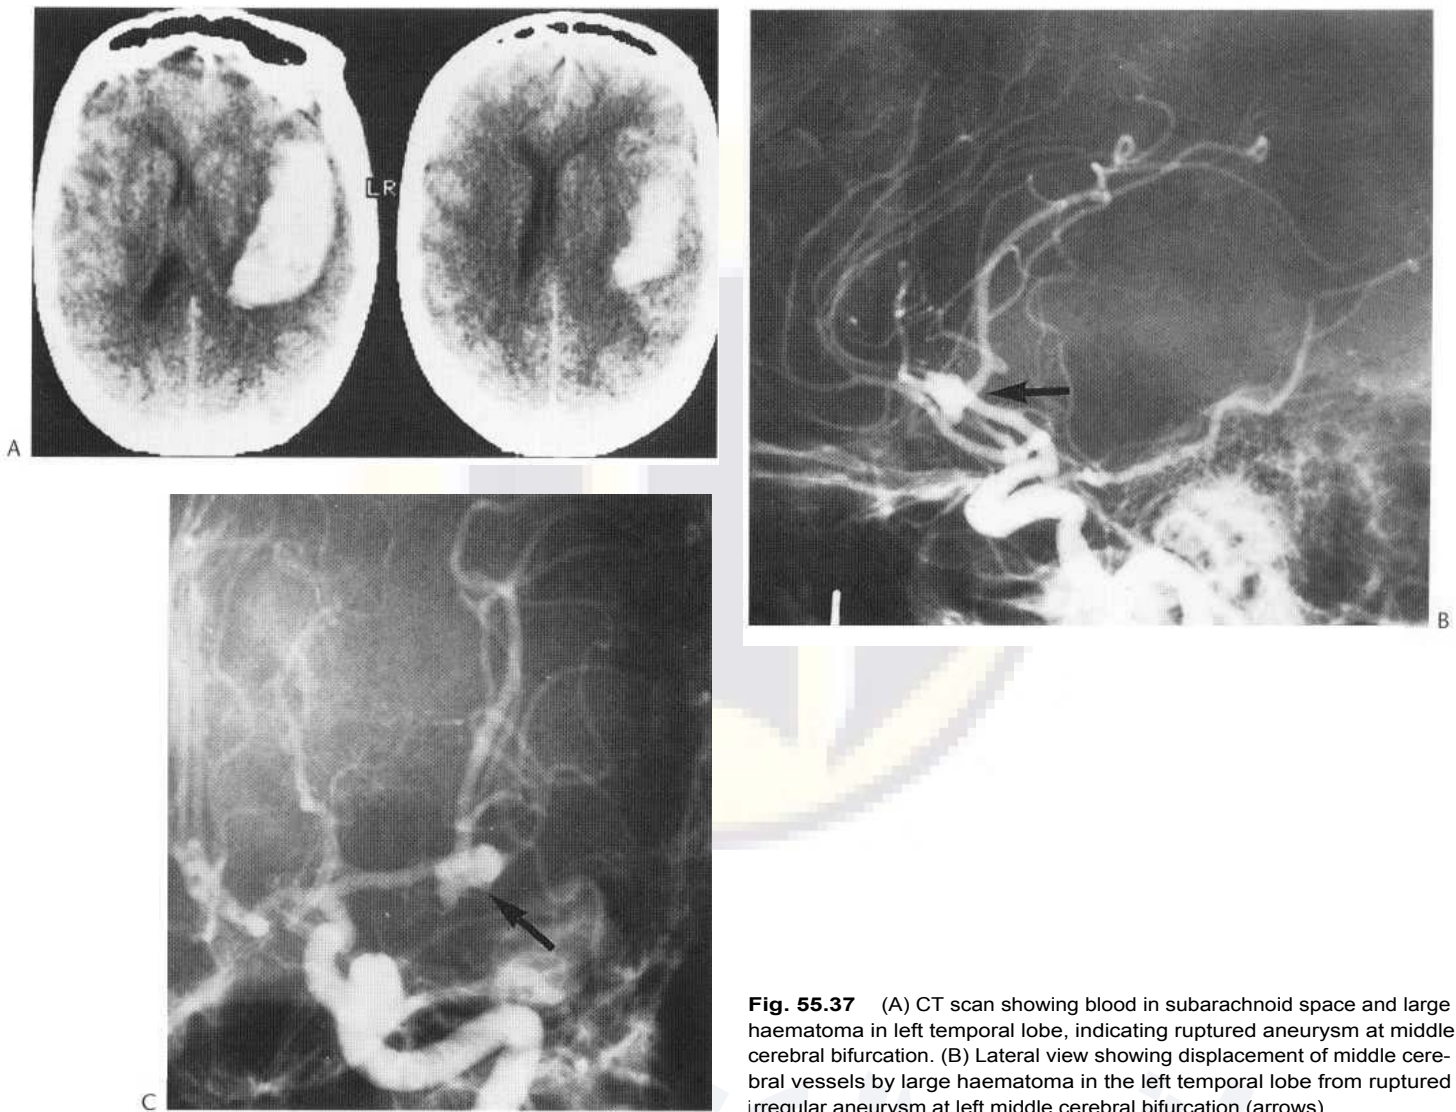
(A) CT scan showing blood in subarachnoid space and large haematoma in left temporal lobe, indicating ruptured aneurysm at middle cerebral bifurcation. (B) Lateral view showing displacement of middle cerebral vessels by large haematoma in the left temporal lobe from ruptured irregular aneurysm at left middle cerebral bifurcation (arrows).
